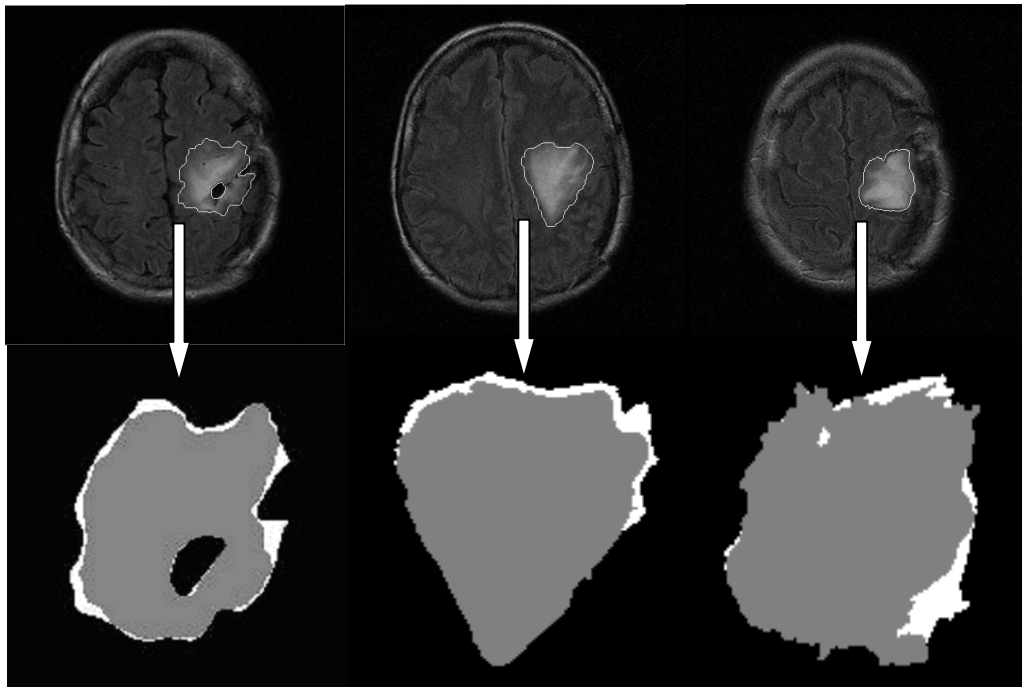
Examples of contour refinement on Patient 1 (FLAIR images)
